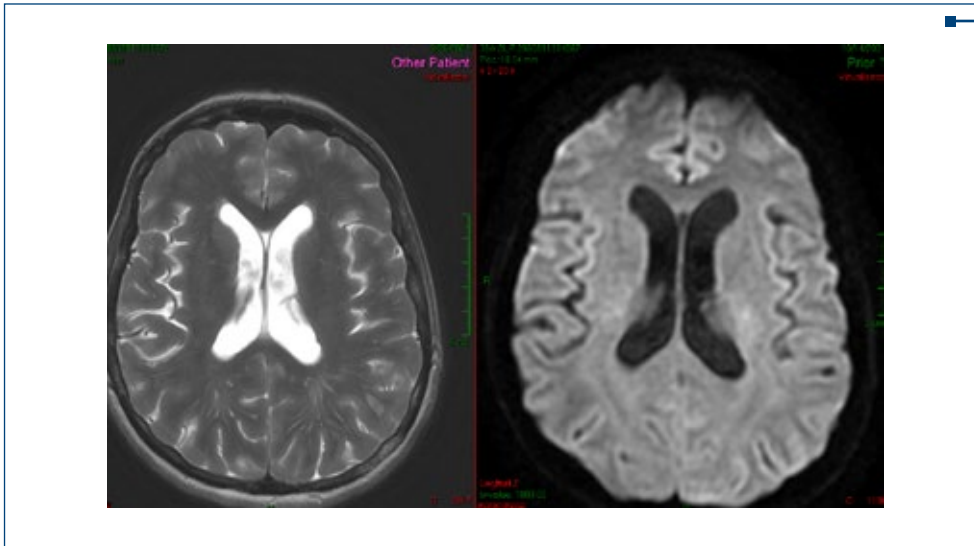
Cerebral MRI: diffusion and 3D FLAIR (in the last sequence, artifacted, the patient had an epileptic seizure, and the examination was interrupted). In the sections performed, a slight enlargement of the ventricular system was noted, with rounded walls (compared to the previous MRI)
